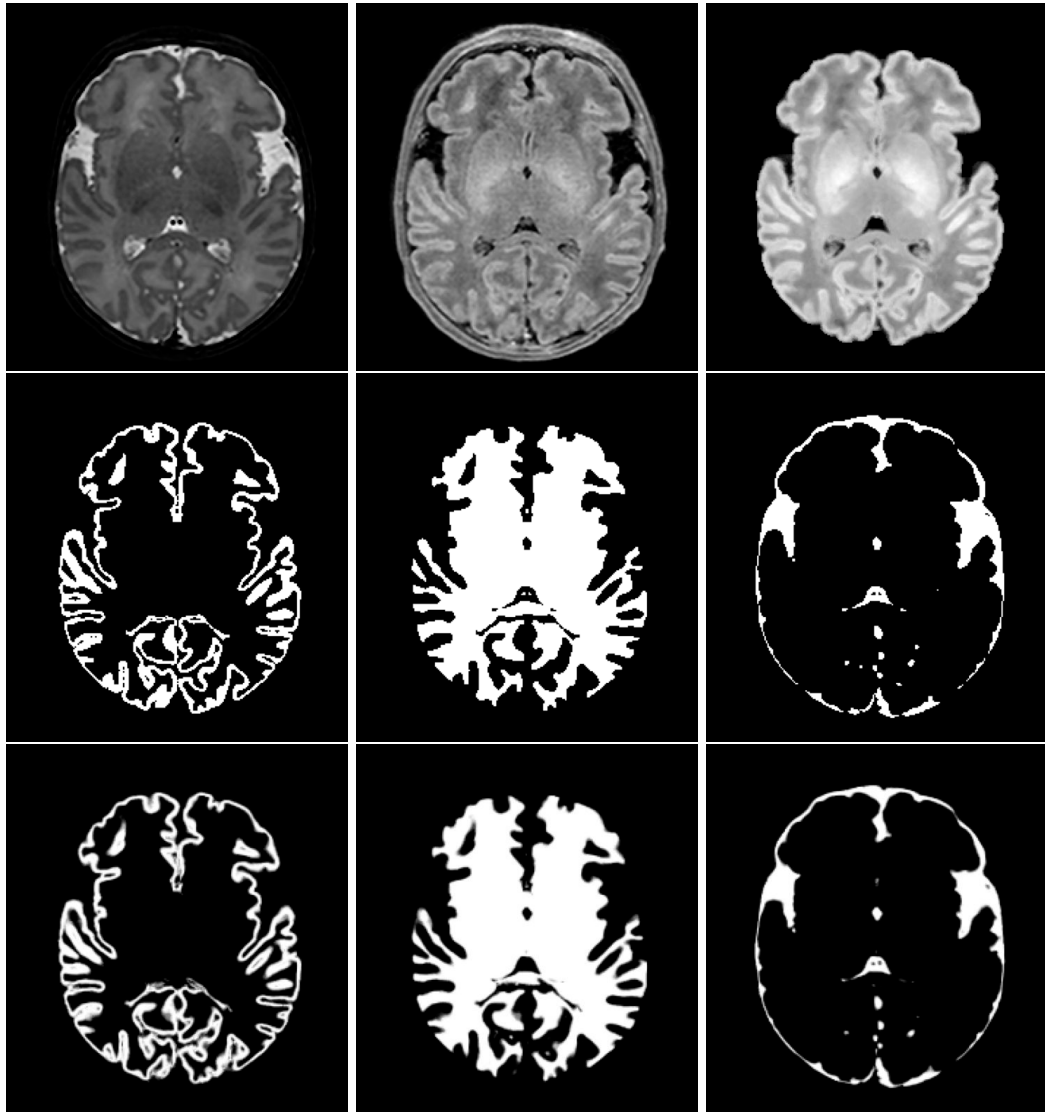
Application of IMAPA in a subject of dHCP dataset for segmenting different brain structures. First row presents the original T2w and T1w MR images with the synthesis of T1w at the right. Second row introduces the reference segmentations of the cortex, WM and CSF, from left to right. In last row, we expose the results of different segmentations performed by IMAPA.
